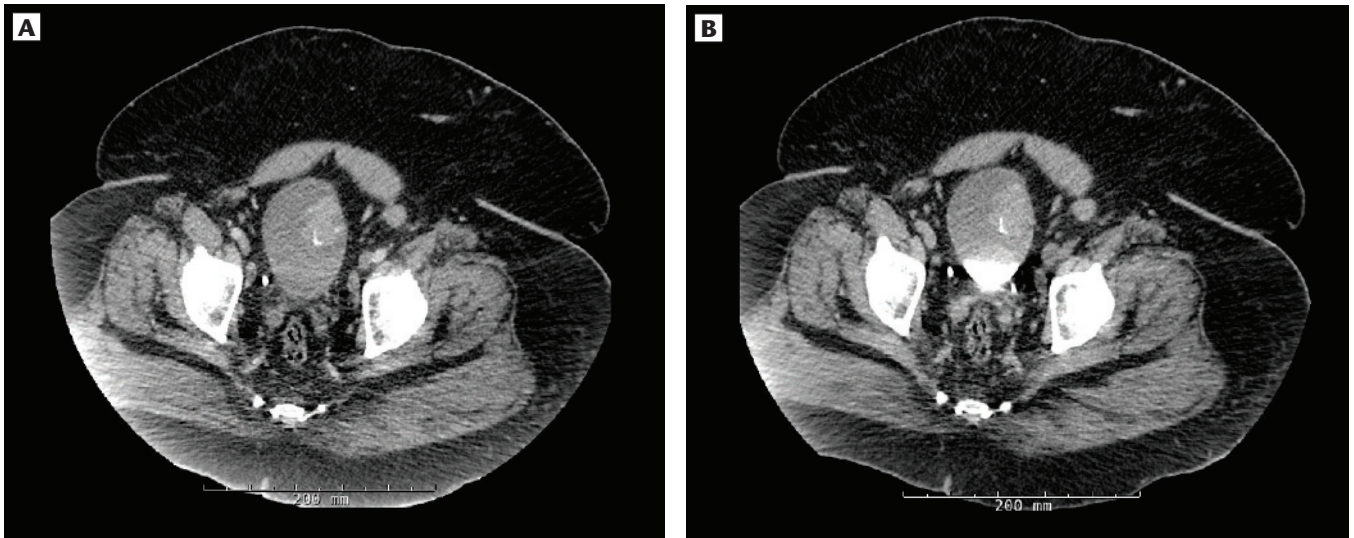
(A) Contrast-enhanced computed tomography image showing bladder mass (arterial phase). (B) Delayed phase.
